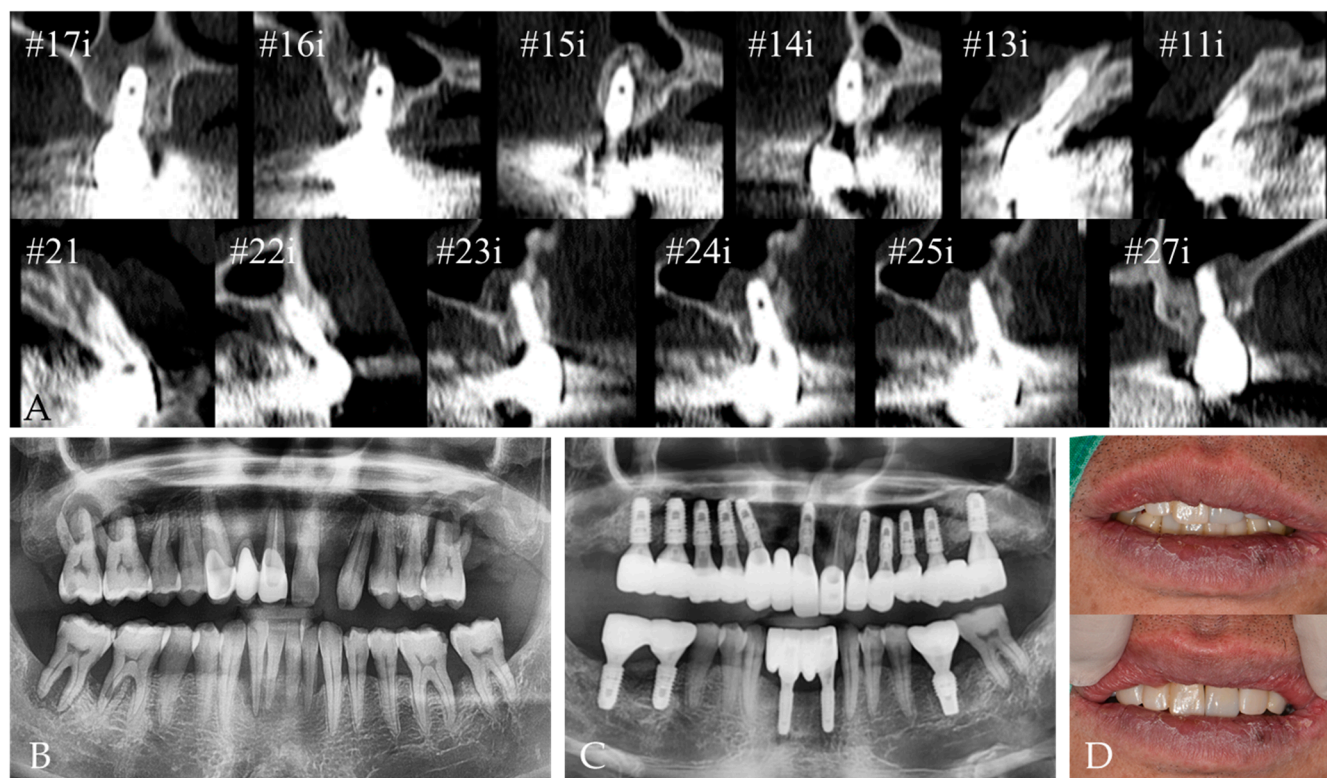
Postoperative radiographs. (A) Post-operative radiographs at 14 months after the surgery. All implants were functioning well with no complications, such as graft or implant failure or marginal bone loss. (B) Pre-operative radiograph. (C,D) At 16 months after the surgery, the implants and grafted bone were well-maintained, with masticatoric and esthetic functions.
